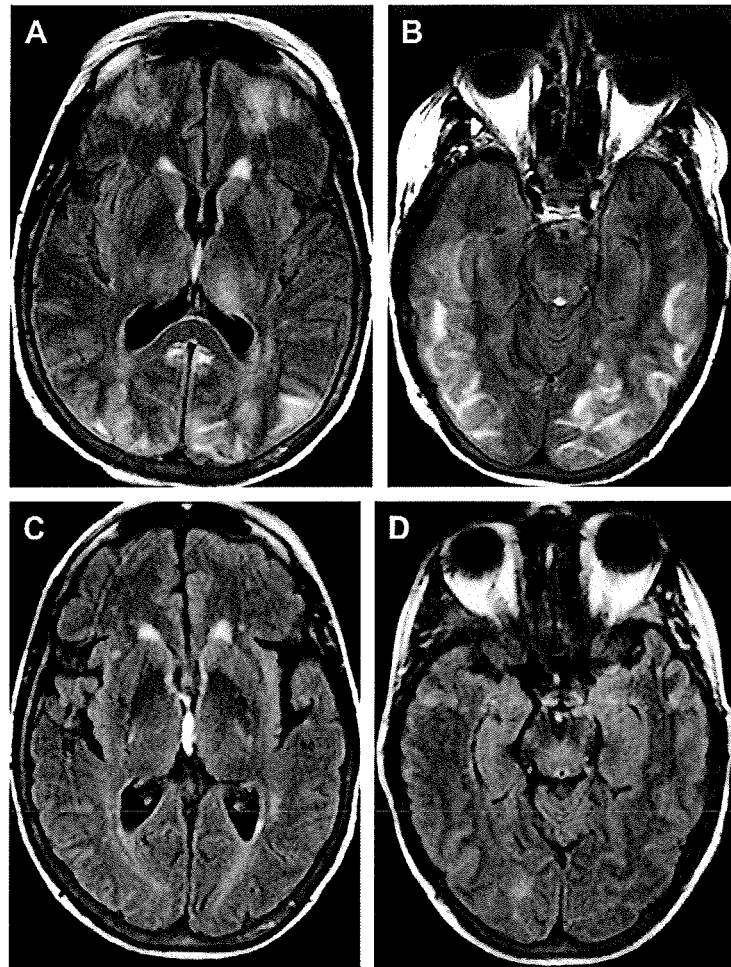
A 59-year-old woman with a history of lupus presented with mental status changes and sepsis. Axial fluid-attenuated inversion recovery (FLAIR) MR images (*A, B*) show increased signal intensity in the cortex and subcortical white matter of the parietal and occipital lobes bilaterally and, to a lesser extent, in the bilateral frontal lobes and left thalamus. Axial FLAIR images obtained on follow-up several months later (*C, D*) demonstrate resolution of the findings without parenchymal sequelae such as encephalomalacia. The findings are consistent with PRES.
